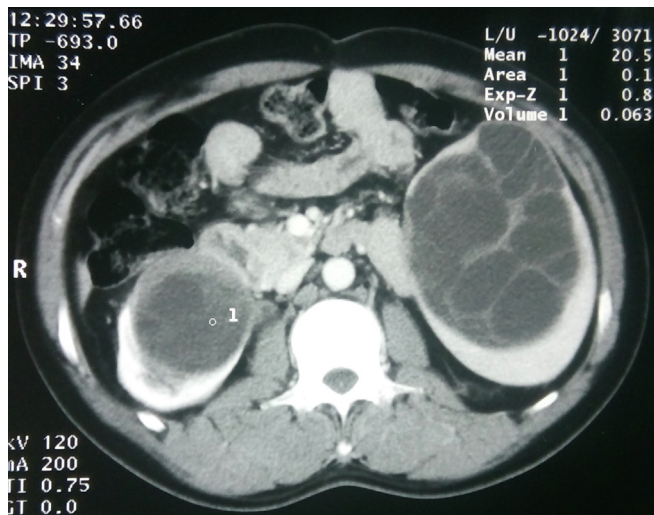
CT: splenic hydatid cyst type III and a right renal hydatid cyst type II of Garbi classification.
